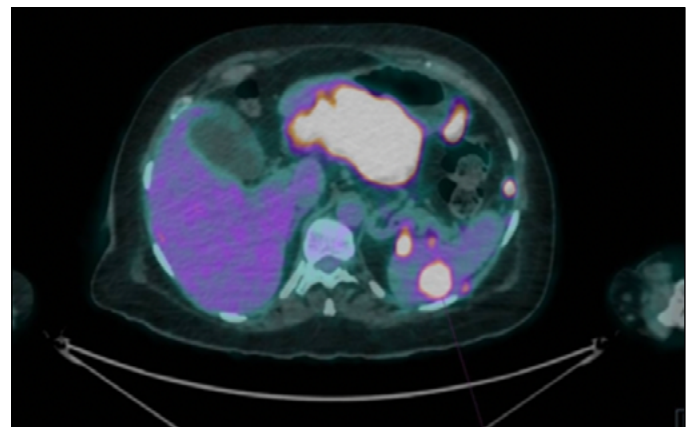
PET-CT scan at diagnosis. Image at gastric level with metabolic activity.
